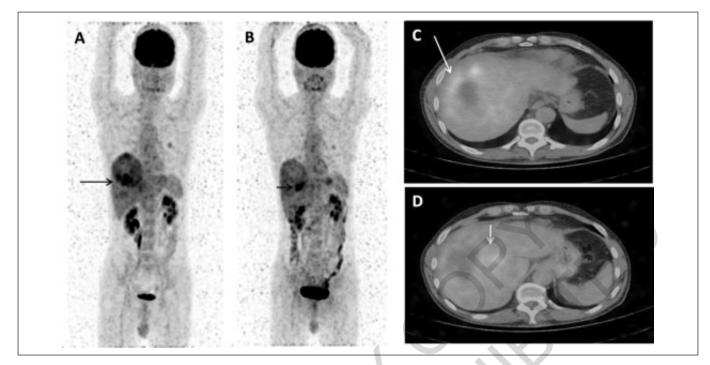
Pre-therapy MIP (A), transaxial slice of FDG-PET/CT fusion (C), and post-therapy MIP (B), transaxial slice of FDG-PET/CT fusion (D) images of a 55 year old male patient with HCC. Long arrows indicate large hypodense solid lesion in upper right lobe of liver with central necrosis and increased FDG uptake (SUV max: 11.3). After 1.6 GBq Y-90 therapy (the dose absorbed by the tumor was 62.2 Gy), the size and metabolic activity of the lesion decreased (SUV max: 5.5) (short arrows) and the findings were evaluated in accordance with the partial response.
